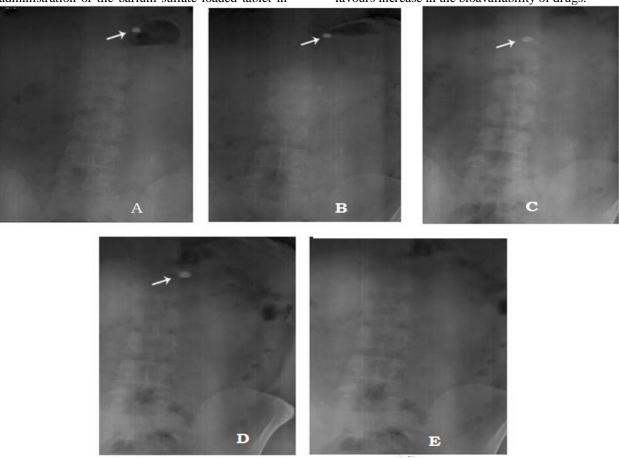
Radiographic images of optimized Cefadroxil floating tablet (F20) in the stomach at different time intervals:
